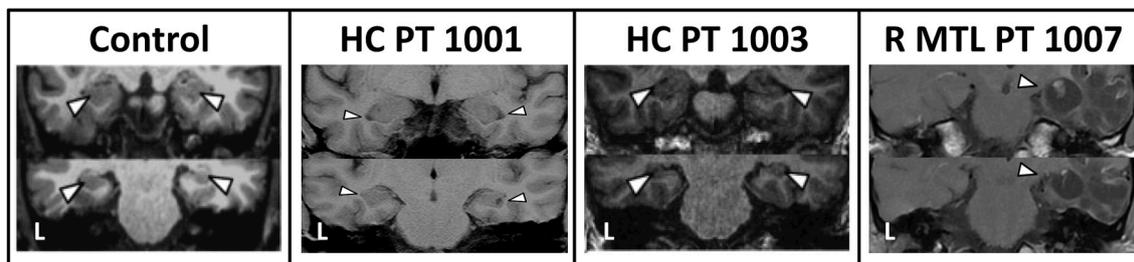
Coronal T2-weighted MRI scans for a healthy control, two patients with selective bilateral hippocampal damage, and a patient with more extensive right MTL damage.
